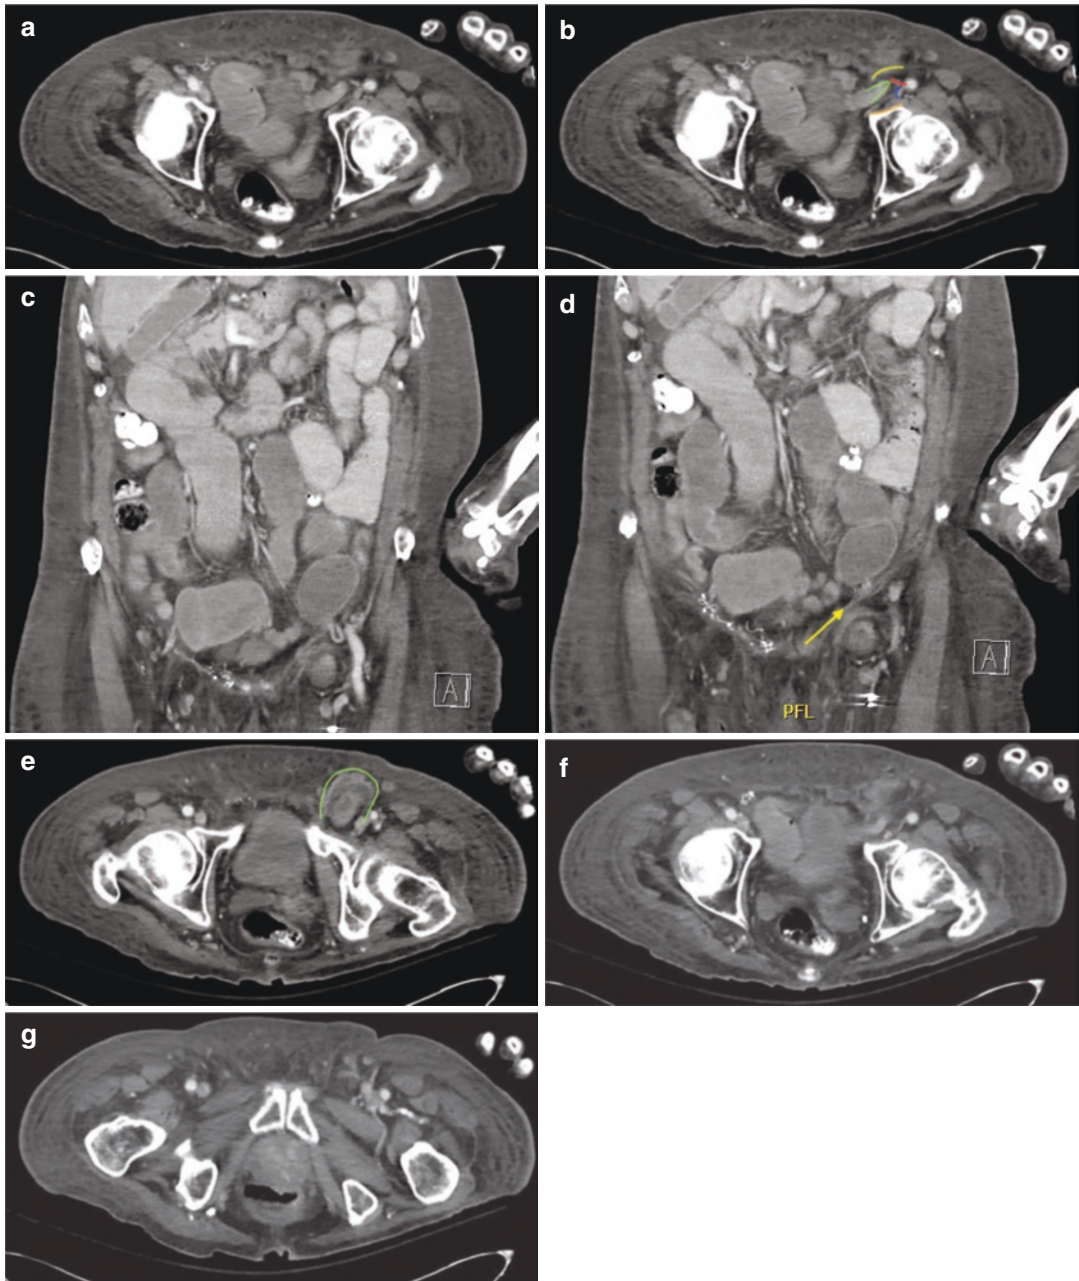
CT scan of a left femoral hernia with strangulated small bowel. (a/b) Note: (i) The presence of the left femoral hernia sac (green) whose origin is inferior to the inguinal ligament (yellow) caudad to the inferior epigastric artery (red) and anterior to the pectineal ligament (orange). (ii) Significant compression of the left femoral vein (blue). (c) Femoral hernia seen just medial to femoral vessels. (d) This image is one slice ventral to the image in Fig. 13.3c, demonstrating that the inguinal ligament is
